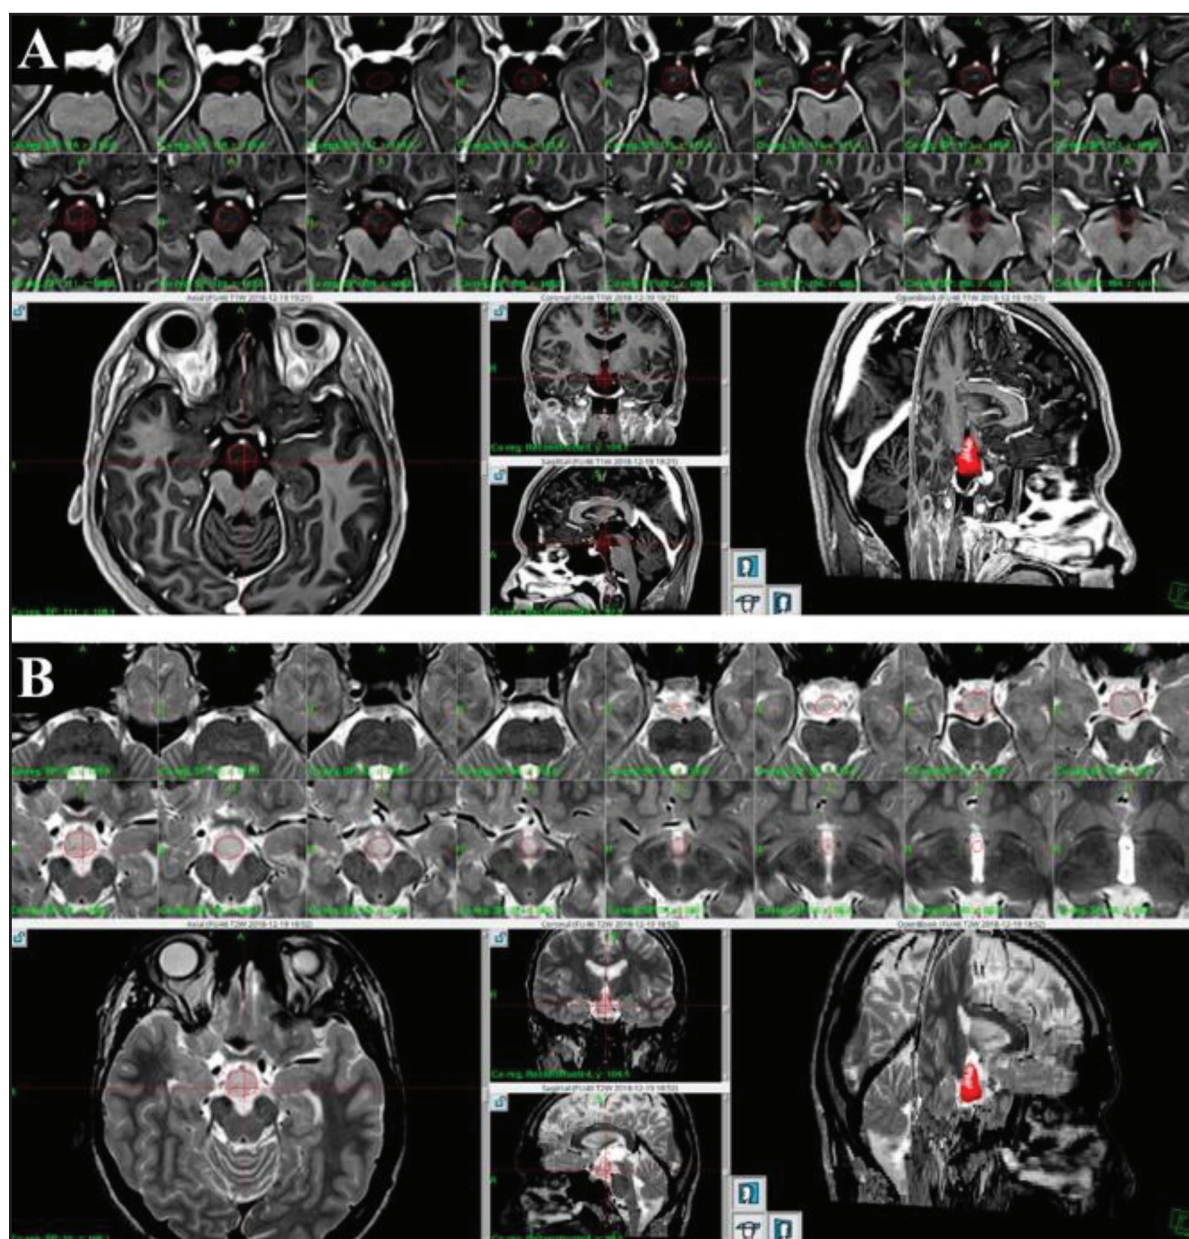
Follow-up MRI of Case 1 at 46 months after GKRS. Axial T1-weighted (A) and T2-weighted (B) images demonstrating stable lesion volume (2.100 cm³) without significant mass effect. Despite minimal volumetric change, the patient achieved substantial clinical improvement with marked seizure reduction (Engel class ID).
